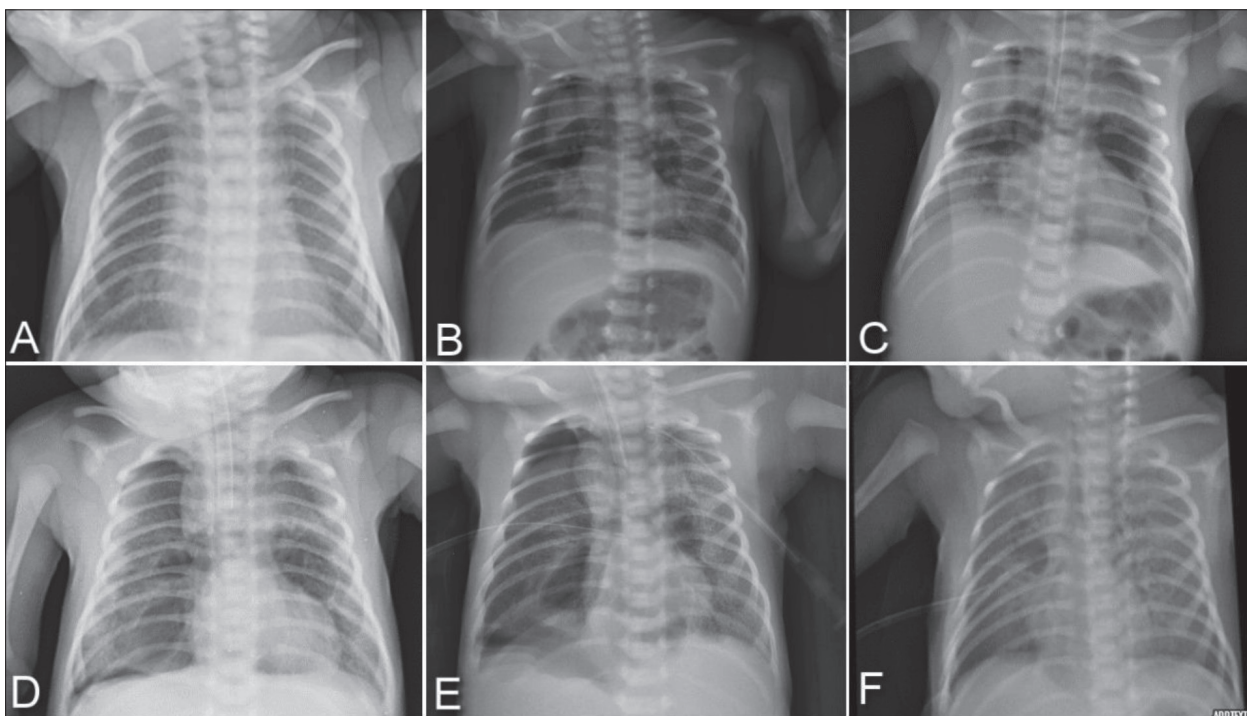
Chest radiographs; on admission, a chest X-ray showed granular lungs with air bronchograms in the central regions (A); after worsening health conditions, chest X-ray showed unusual pneumomediastinum – a central area of radiolucency projected over the mediastinum, giving the classic “spinnaker-sail” sign (B before and C after intubation); chest X-ray after seven hours showed the typical “angel-wing” sign – bilateral hyperlucency representing air leak into the pleural cavities – pneumothoraces (D), which required bilateral thoracic drainage followed by chest tube placement (E); a repeat chest X-ray was performed at the age of nine days, which showed partial resolution of the pneumomediastinum and gradual improvement of the patient’s symptoms; the patient was extubated (F)
